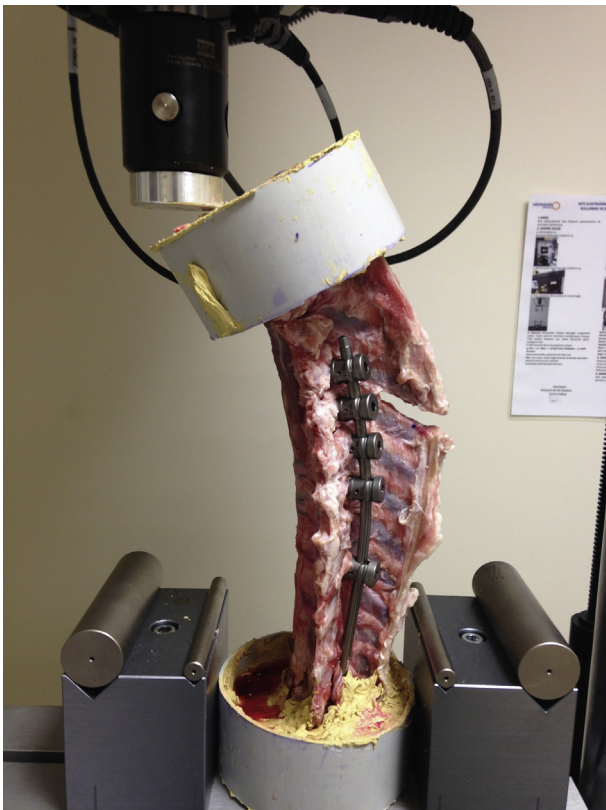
All spines were instrumented with pedicle screws at the 5 vertebral levels between the T2 and T7 vertebrae. Anterior-posterior and lateral radiography view of the spine.
